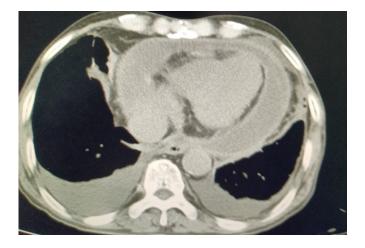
Chest computed tomographic scan shows the significantly thickened and calcified ring of pericardium.
